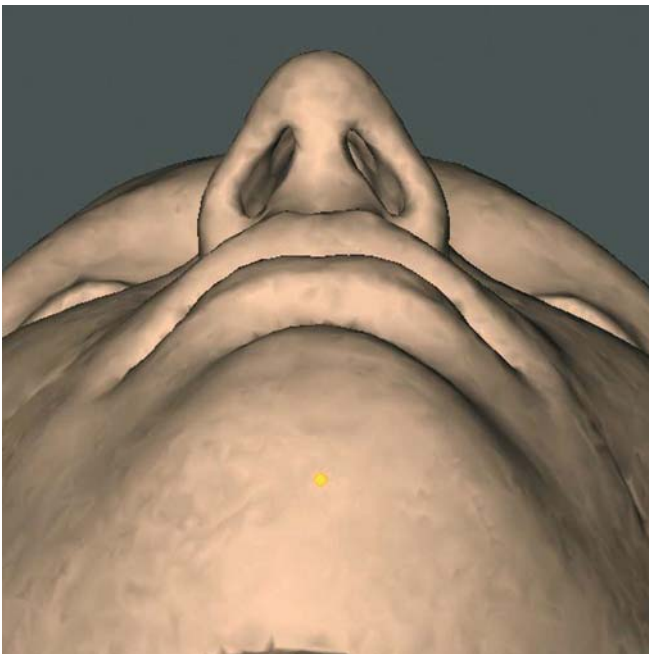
Soft tissue gnathion. Base view (3-D CT, patient K.C.)
